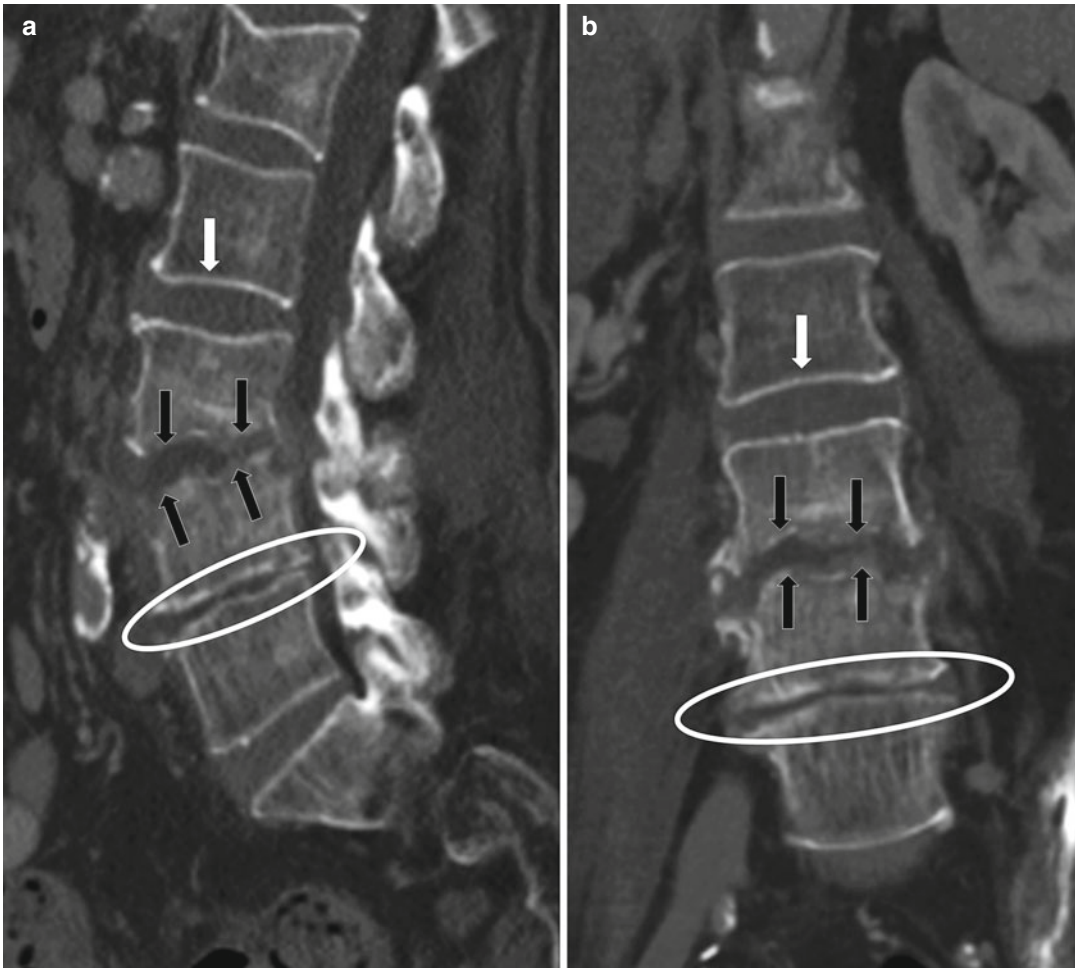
A 69-year-old male 2 months following posterior interspinous fusion surgery. Patient had subsequent postoperative infection with *Staphylococcus aureus* with ongoing and worsening low back pain and radicular leg pain. Sagittal (a) and coronal (b) reconstructed CT images show the typical endplate destructive changes of diskitis/
